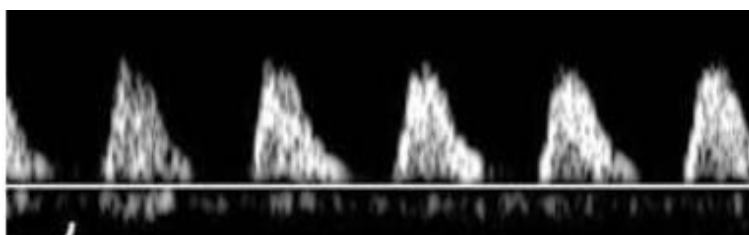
FIGURE III C : UMBILICAL ARTERY DOPPLER WITH ABSENT DIASTOLIC FLOW
